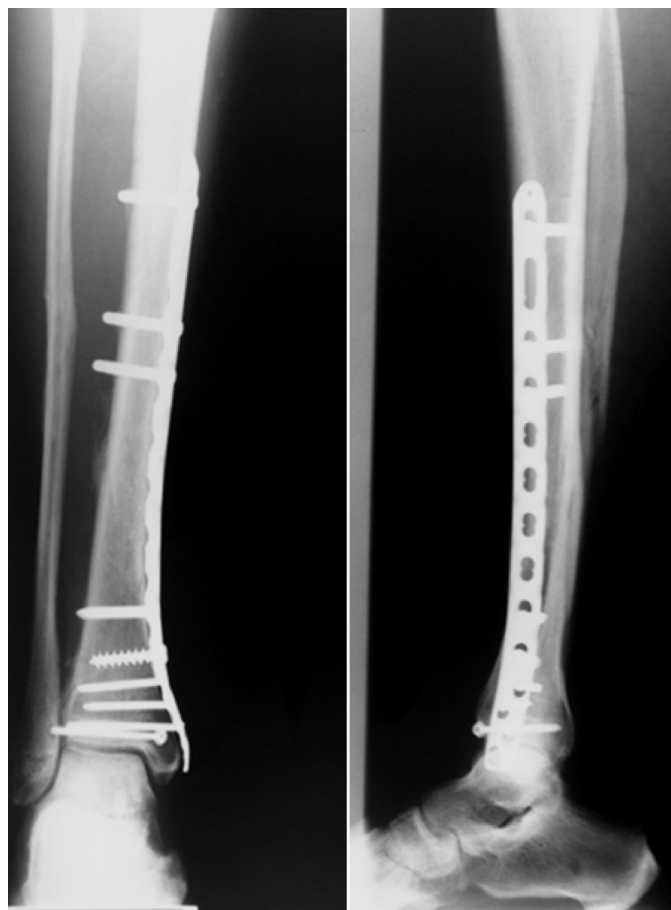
X-ray at 3 months after surgery (DLS screws on the proximal side of the fracture).
